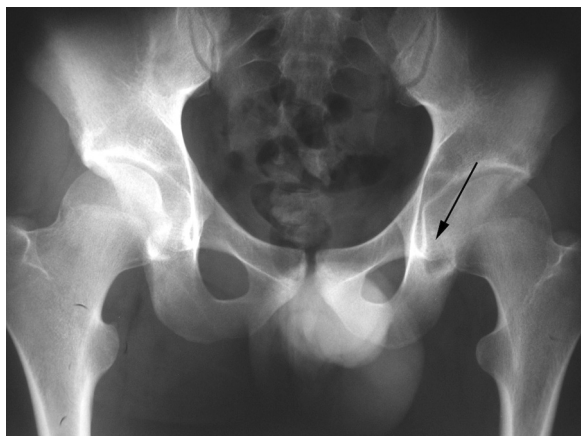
Pelvis radiograph shows a lytic lesion in posterior acetabular column (arrow).
